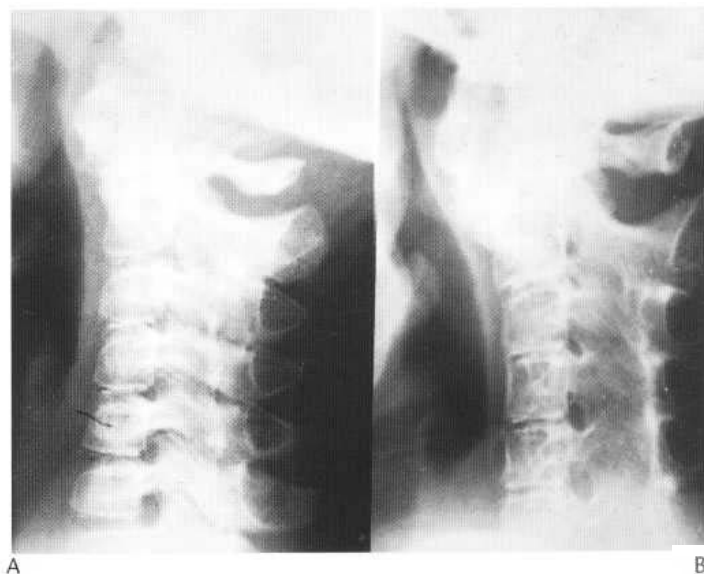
Juvenile chronic arthritis. (A) The early radiograph in this patient shows hypoplasia of the vertebral bodies and a widened cervical canal. (B) Subsequently the vertebral bodies and facet joints ankylose, with failure of development.
